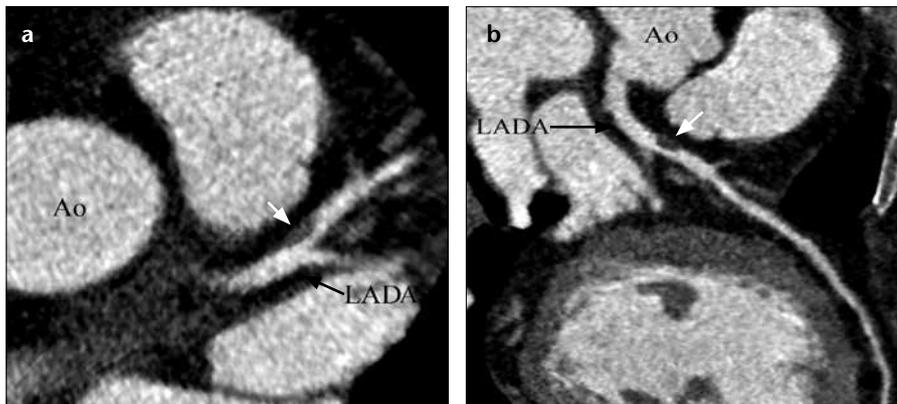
a, b. A 53-year-old woman presented with angina pectoris and three risk factors which are diabetes mellitus, hypertension, and hyperlipidemia. Axial (a) and curved planar reformatted (b) CT angiography images reveal a noncalcified soft plaque (white arrows), a significant ($\geq 50\%$) stenosis in the mid-segment of the LAD artery (Ao, aorta; LADA, left anterior descending artery).
